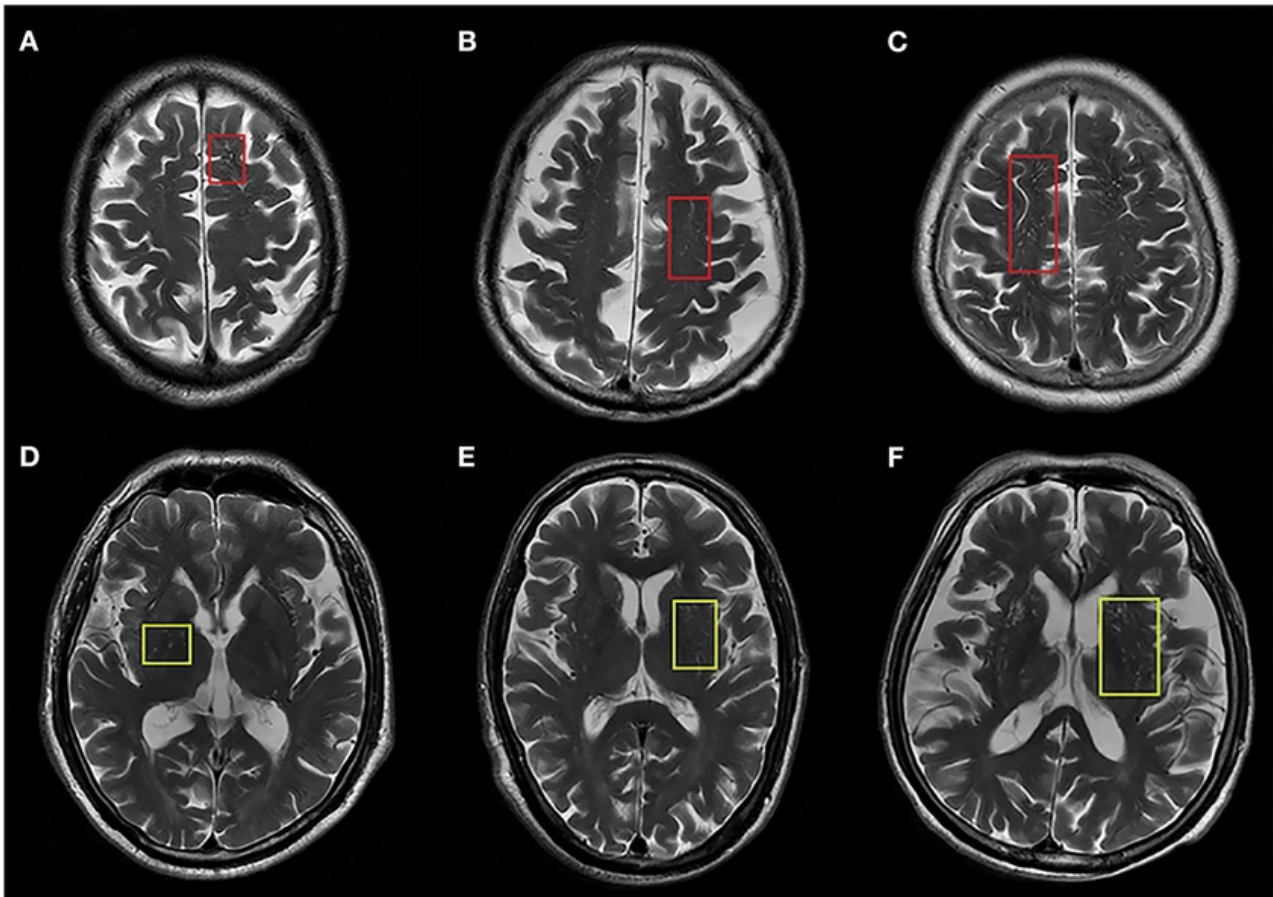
Representative axial T2-weighted MRI images of ePVS in centrum semiovale (PVS-CSO) and basal ganglia (PVS-BG). (A–C) Indicate PVS-CSO with red squares corresponding to degree of severity. (D–F) Indicate PVS-BG with yellow squares corresponding to degree of severity (Shen et al., 2021).
